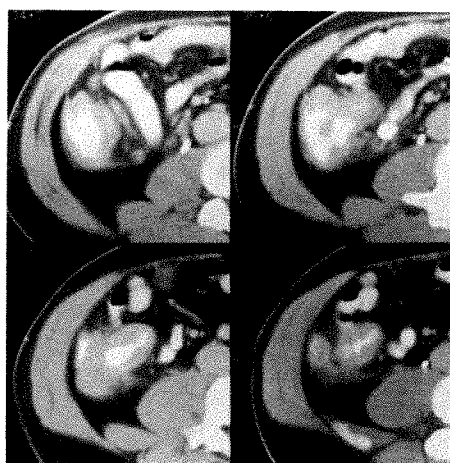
Second patient with idiopathic cecal ulcer. Contiguous CT images of cecum and terminal ileum show diffuse homogeneous wall thickening and pericolonic stranding.
